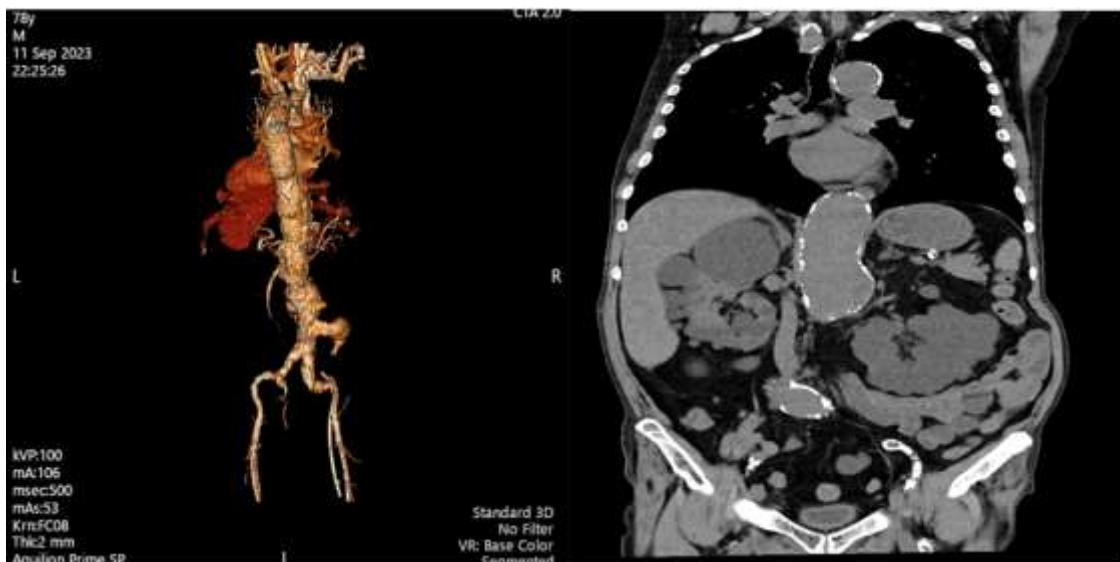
and Fig. 2. Computed tomography angiography (CTA) of the thoracic and abdominal aorta showing dilated, tortuous aorta with advanced atherosclerosis along and significant atheromatous plaques, presenting in concentric form and mixed character of calcifying plaques and intramural hematomas almost along its entire length.
